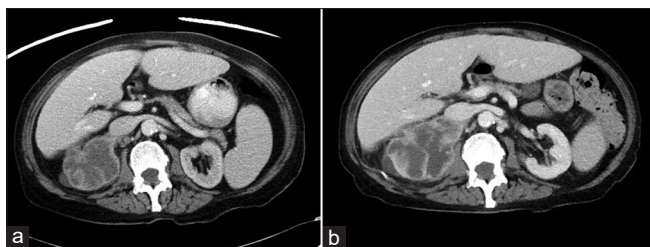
(a) Initial computed tomography scan demonstrating a 5.9 × 5.3 × 6.1 cm heterogeneous mass-like lesion arising from the upper pole of an atrophic right kidney with a single prominent retrocaval lymph node measuring 1.1 cm, with no evidence of further metastatic disease. (b) Repeat computed tomography scan 20 days after the initial computed tomography scan, demonstrating rapid progression of disease. New 0.5 cm × 7.0 cm × 6.8 cm area of cystic change and necrosis within the mass, and local invasion of the renal mass into the right psoas muscle, and the right renal vein abutting the right vena cava with encasement of the solitary right renal artery within the mass
